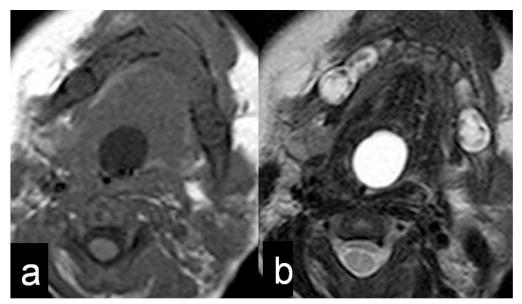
Case 1. Axial magnetic resonance imaging, MRI (a) T1-weighted and (b) T2weighted showing the same cystic mass in Figure 1 obliterating the airway.
